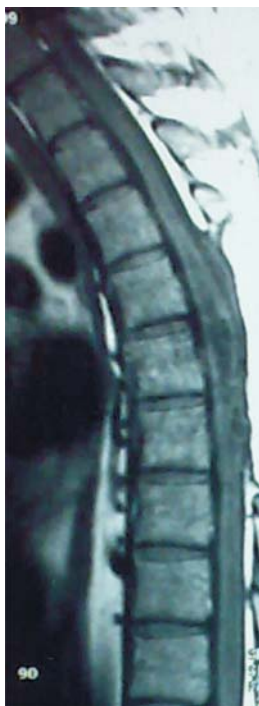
MRI image showing extensive syrinx involving cervico-dorsal cord.
